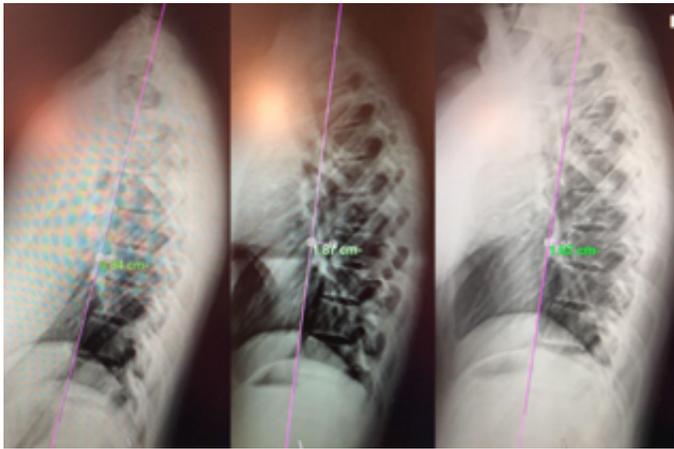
Lateral thoracic radiographs. Left: Initial; Middle: Post-treatment; Right: Follow-up. Measurement shows an increase from 0.84cm to 1.62cm distance from mid-height anterior T8 to the line intersecting mid-height anterior T4-T12. This distance is diagnostic for SBS when <1.2cm (24).
